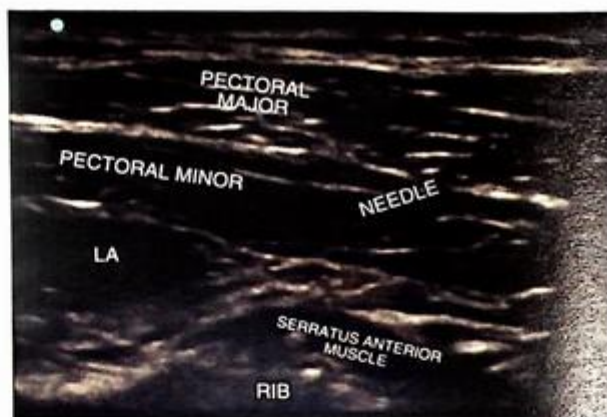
Ultrasound image of PECS 2 shows the position of the needle and the LA deep to the pectoralis minor muscle.
